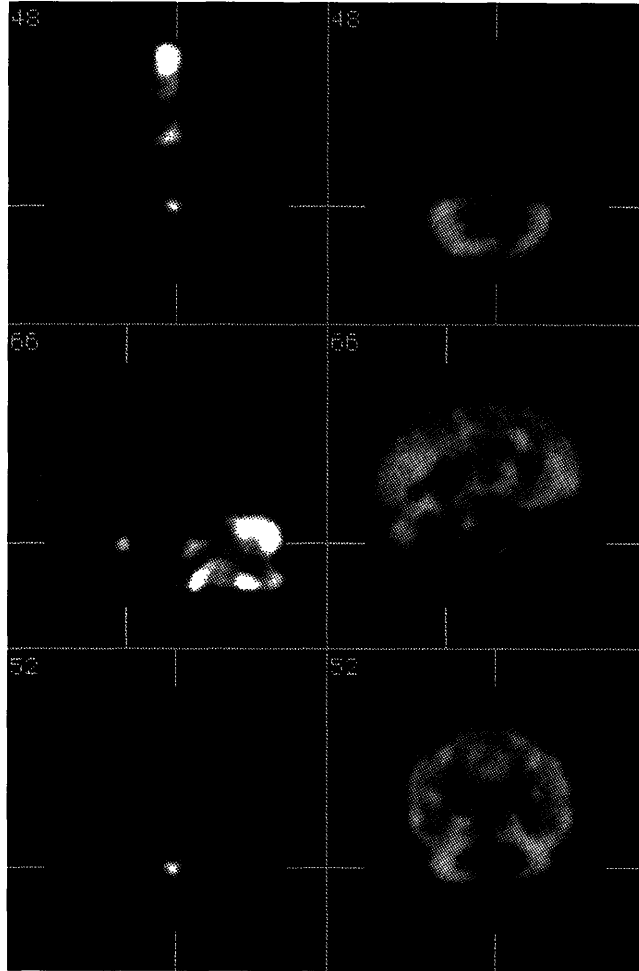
Posterior fossa tumor shown on ^{201}Tl -SPECT (left), and $^{99\text{m}}\text{Tc}$ -HMPAO-SPECT (right). On the left image, bright corresponds to high ^{201}Tl uptake, while dark corresponds to low or no uptake. On the right image, bright corresponds to high perfusion, while dark corresponds to low perfusion.
